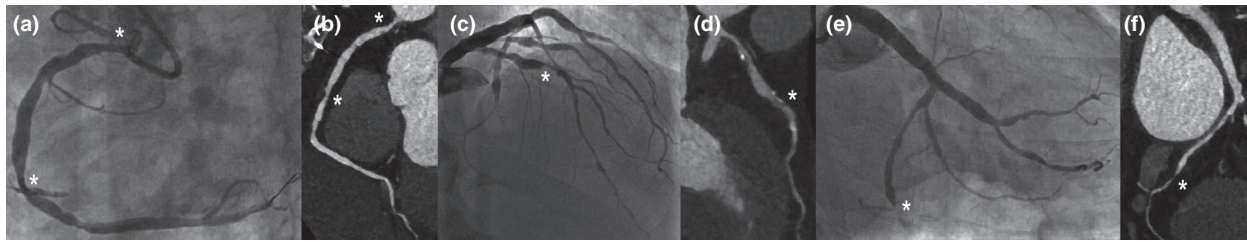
A case example of severe CAV in a 63-year-old man 29 years after HTx. The right coronary artery showed intermediate stenoses in the proximal and distal segments on ICA (a) and CCTA (b). The left anterior descending artery showed an intermediate stenosis in the middle segment on ICA (c) and CCTA (d). The circumflex artery showed severe stenosis in the distal segment on ICA (e) and CCTA (f). CAV: cardiac allograft vasculopathy; CCTA: coronary computed tomography angiography; HTx: heart transplantation; ICA: invasive coronary angiography.
